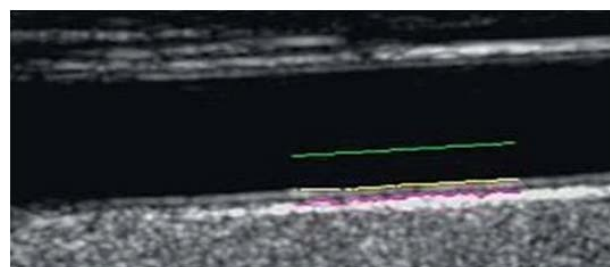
Ultrasound image of carotid intima media
